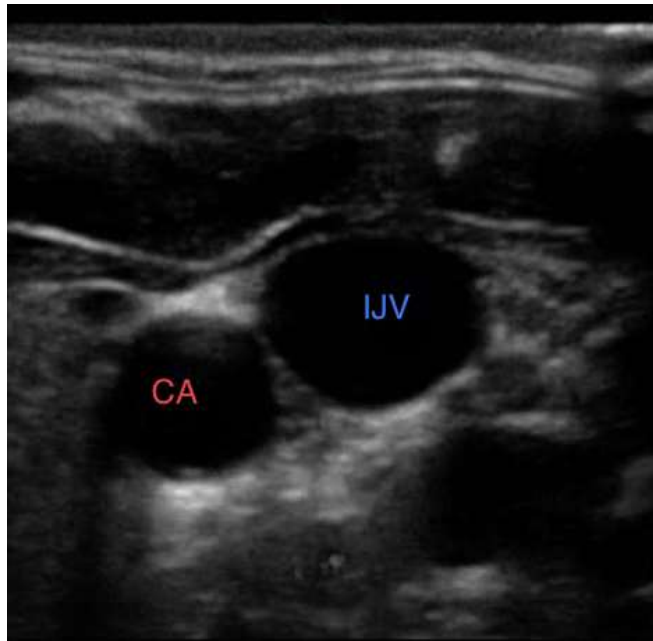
Ultrasound image of internal jugular vein (IJV) out of plane method- anterolateral position of IJV to carotid artery.
